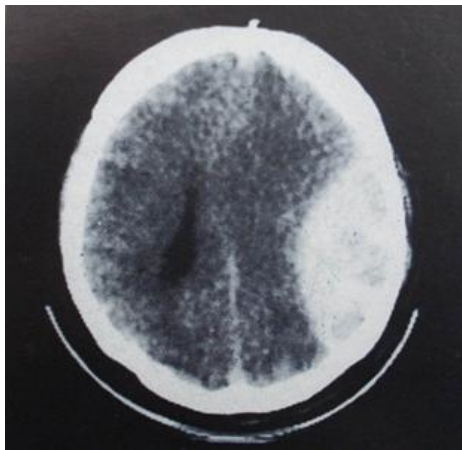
CT image of epidural hematoma
